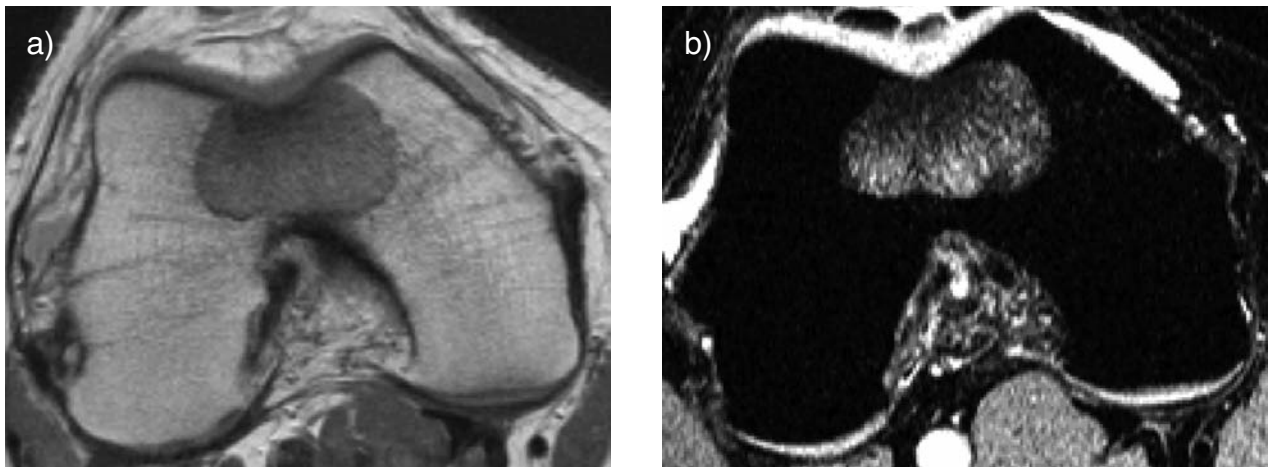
MRI proton density (a) and STIR (b) sequences, axial views. At the level of the femoral condyles, note a 3 cm hypointense (a) and hyperintense (b) round lesion with distinct margins
